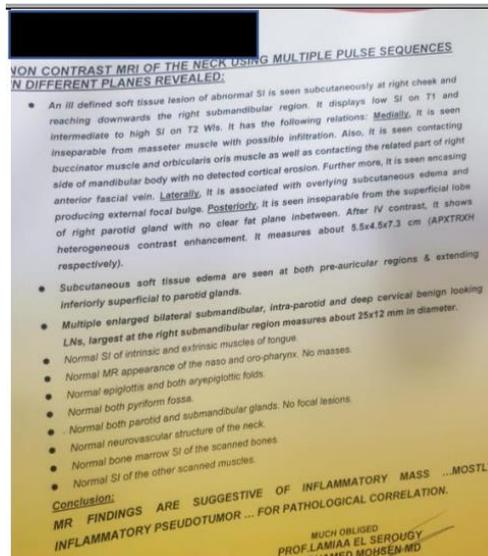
Non contrast MRI show inflammatory pseudotumor.
